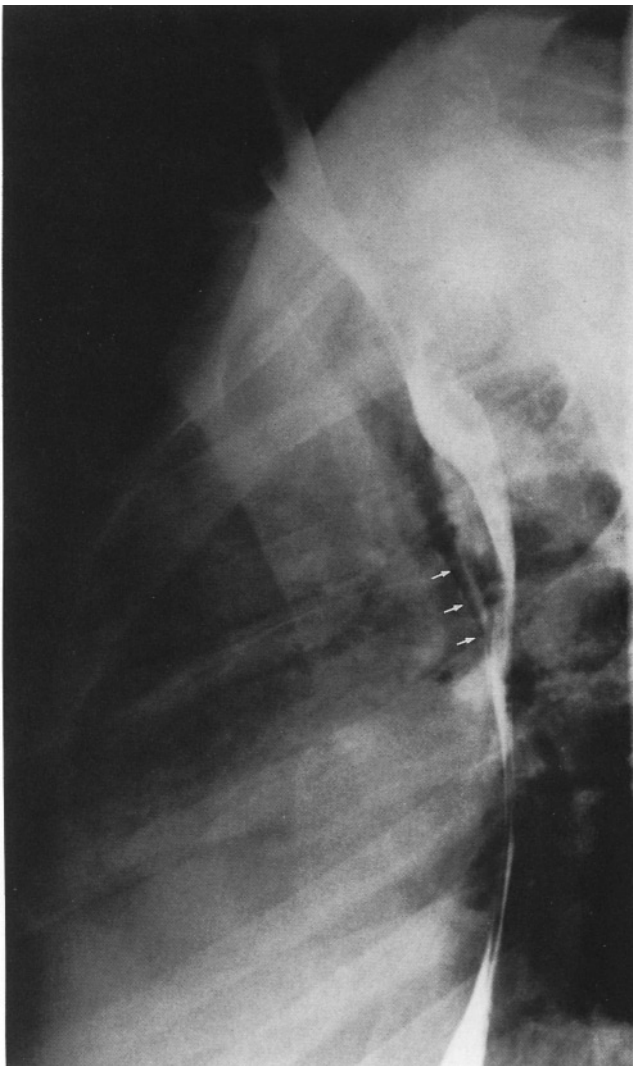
Lateral chest radiograph with barium in the esophagus. An anterior mediastinal mass is visible, compressing the trachea at the carina posteriorly (arrows).
